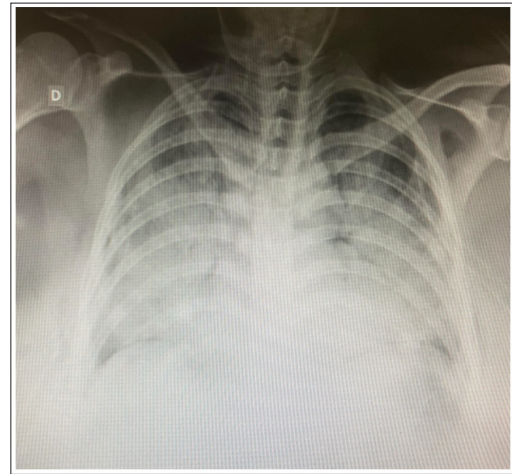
Pre-Lavage Chest Radiograph
